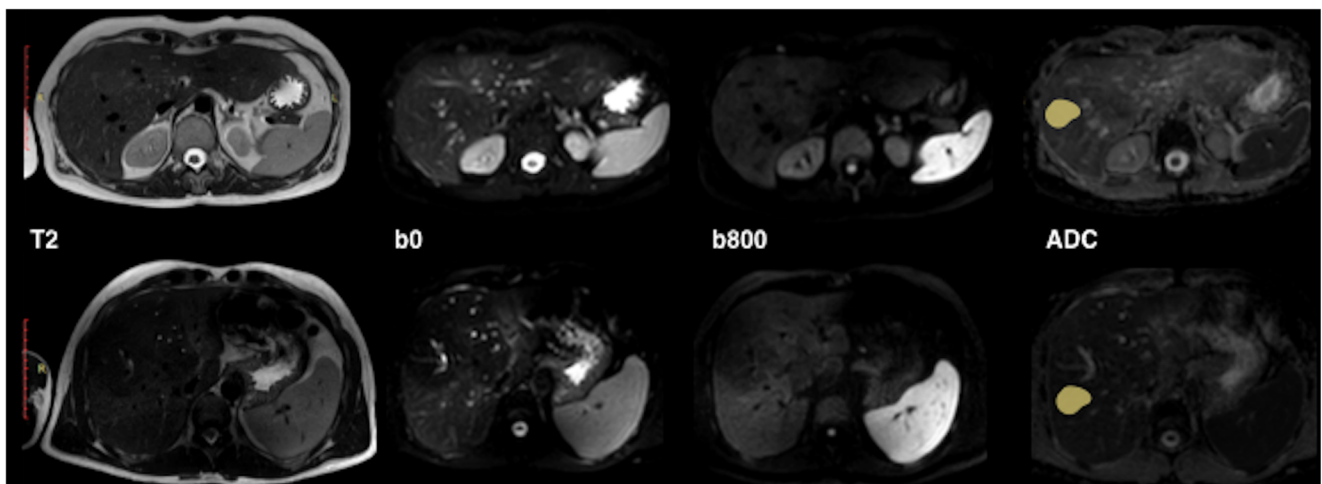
Axial DWI images and ADC-map of two PSC patients. Left to right: T2-weighted image, DWI b=0; b=800; and ADC-map including example of region-of-interest. Upper row: 34-year-old female patient fibrosis stage F0/1; lower row: 35-year-old male patients fibrosis stage F4
